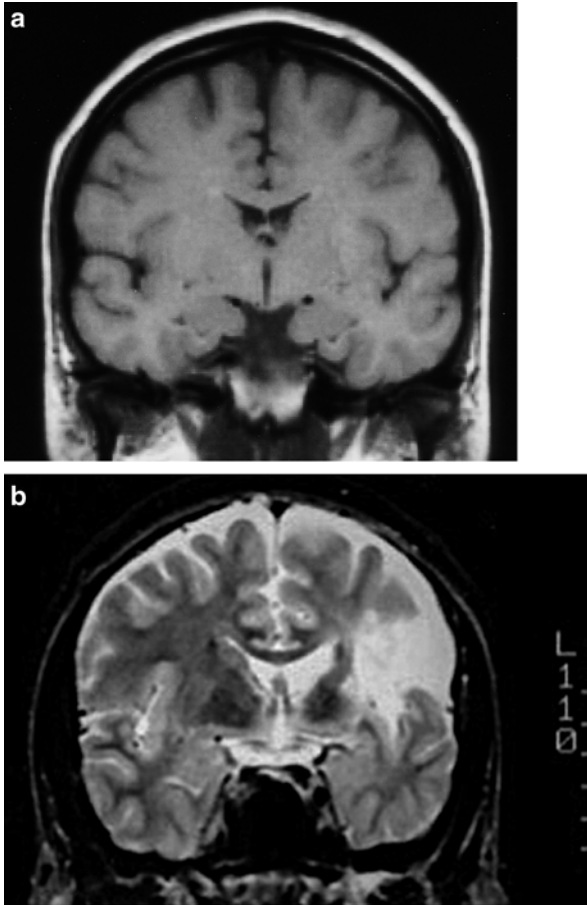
CVA. (a) is an MRI which shows the appearance of a normal patient at the level of the frontal operculum, while (b) is an MRI which shows an infarct in the cortical territory of the left superior branch of the middle cerebral artery in the frontal lobe with similar neurological findings to Case One (From Jacobson and Marcus [17])
